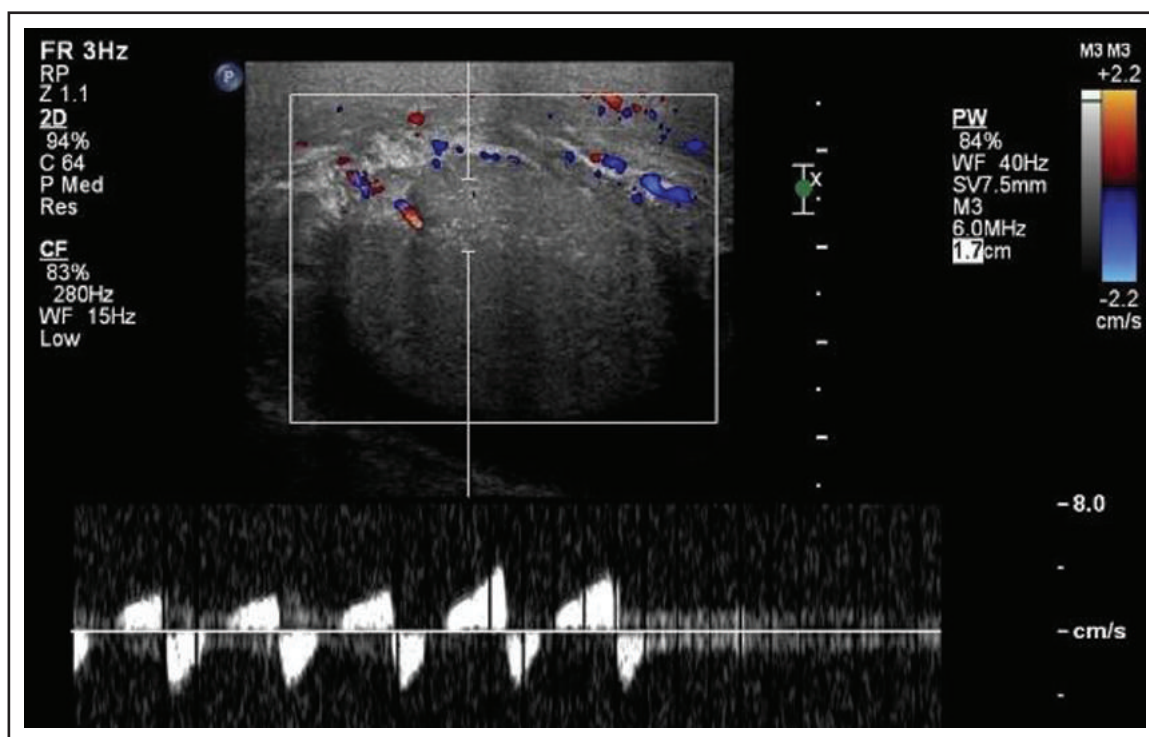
Spectral Doppler. Sagittal image colour flow showing decreased perfusion and spectral analysis demonstrating high resistive-flow patterns with the reversed end-diastolic flow.
